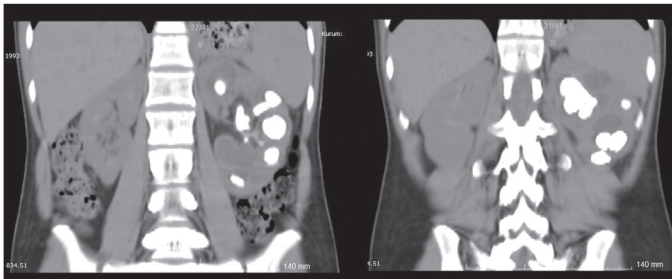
Preoperative multipl stones in the left kidney on computed tomography
